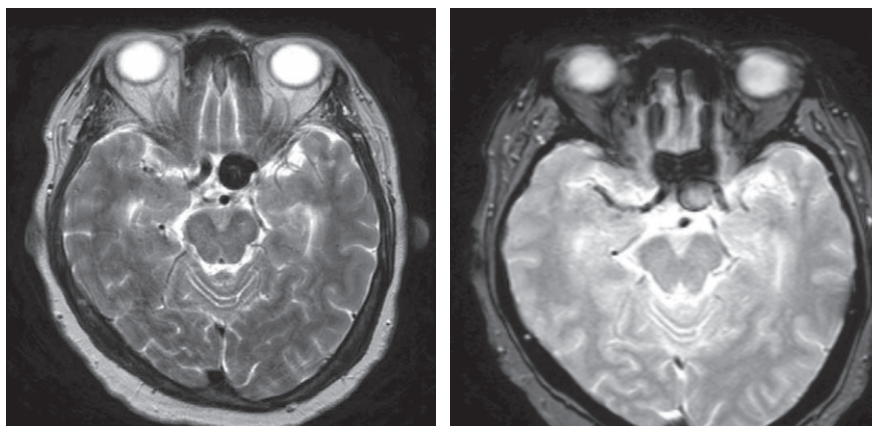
(Left) T2-weighted axial MRI with flow void and (Right) T2-weighted axial MRI post gadolinium contrast administration highlighting a 1.5 x 1.3 cm left ophthalmic segment internal carotid artery aneurysm.
